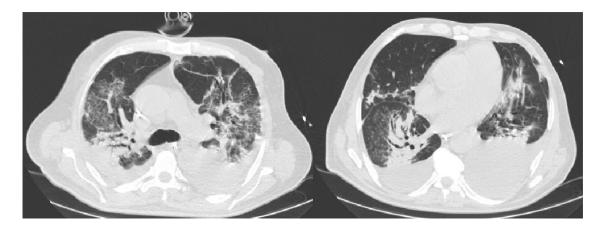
Initial chest CT: Multilobar ground glass opacities, peribronchovascular basal areas of consolidation and free bilateral pleural effusion.
